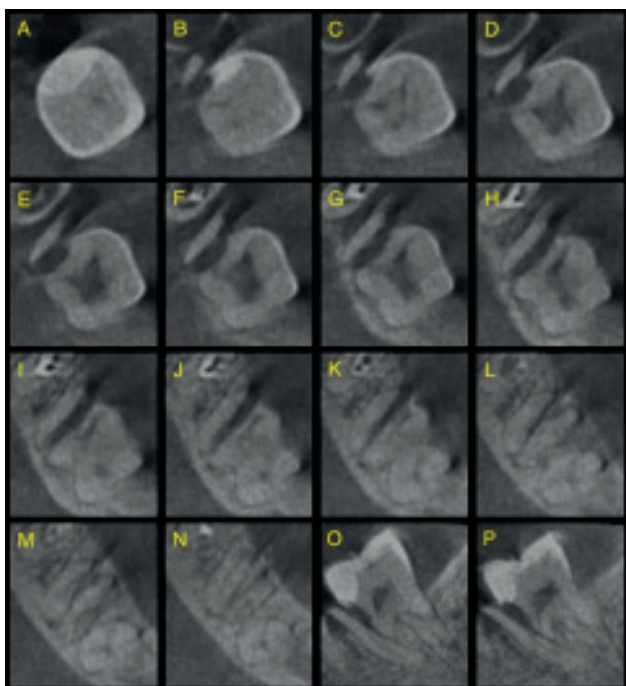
A cone beam computed tomography scans of tooth 47 performed 2 days after the 1st visit: (A–N) consecutive axial cone beam computed tomography images; (O–P) selected sagittal cone beam computed tomography images
